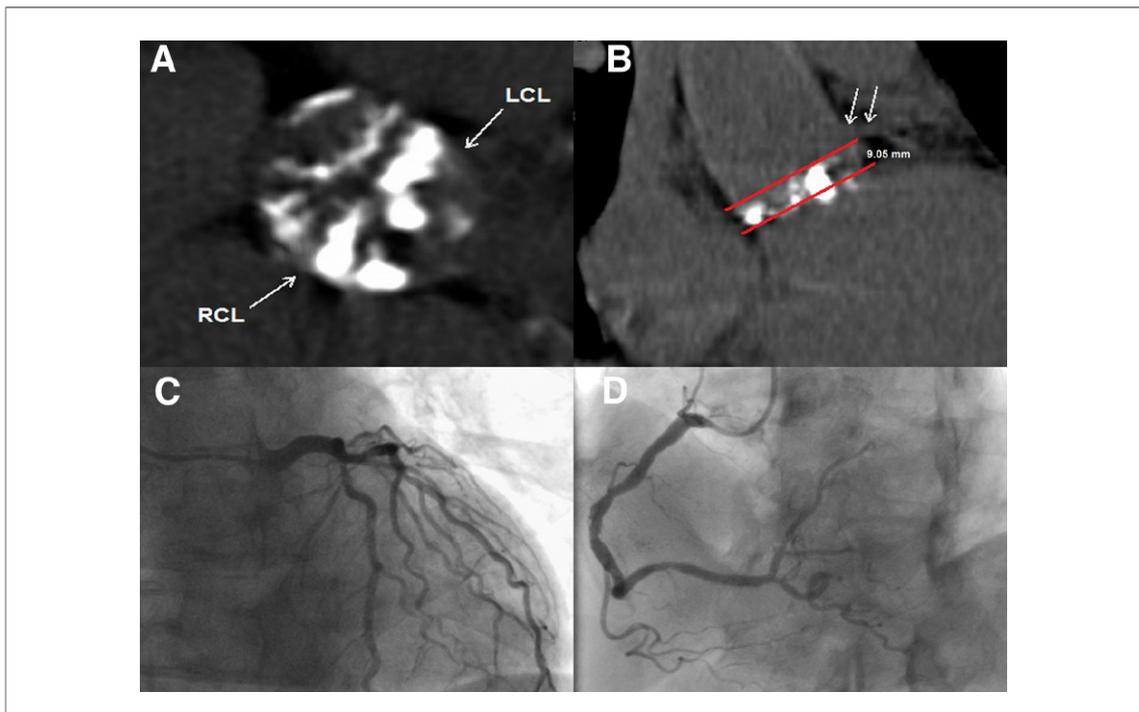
Baseline Computed Tomography and Coronary Angiography
